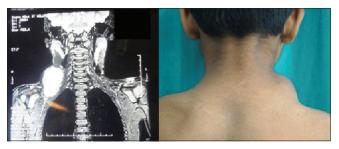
Magnetic resonance imaging can easily delineate deeper extension of the lesion
